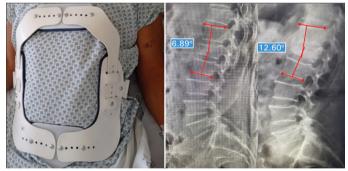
Thoracolumbar orthosis with Jewett-type 3-point stabilization and radiographs showing an example of a Cobb angle of 6.89° pre-treatment and 12.60° post-treatment.
